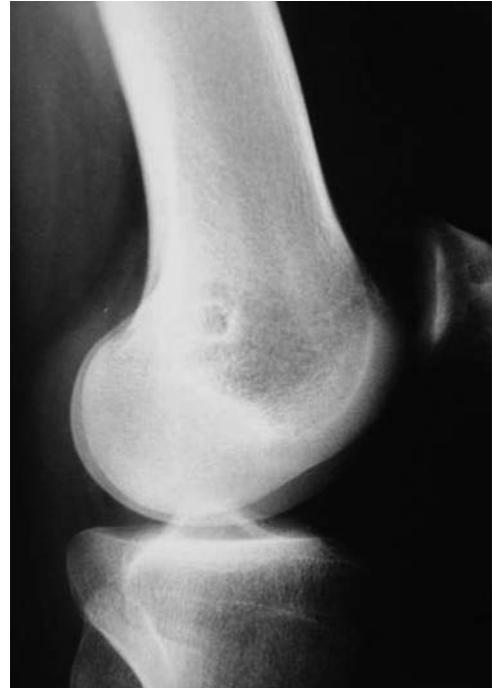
Good positioning on radiographs with Schöttle and squares methods.
